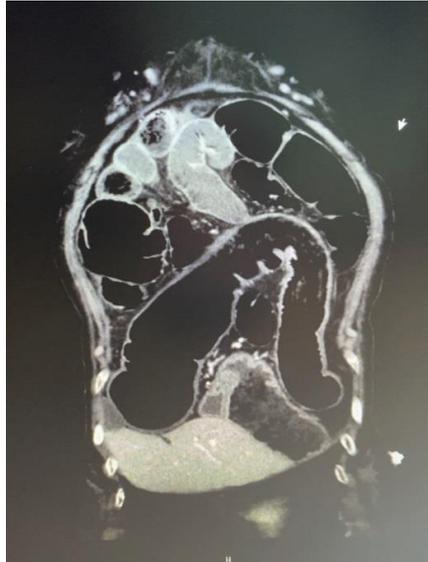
Abdominal computed tomography (CT) shows normal rectum, dilatation of the distal sigmoid colon and other colonic and ileal loops.
